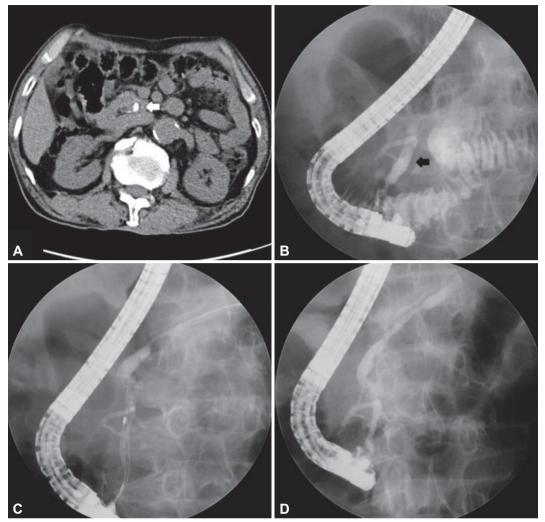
Endoscopic intervention after extracorporeal shock wave lithotripsy (ESWL) for fragmentation of large stone. (A) Abdominal computed tomographic scan shows 10 mm sized calcified stones (white arrow) in pancreatic head within markedly dilated pancreatic duct. (B) Large pancreatic duct stones in the pancreas head (black arrow) rendered the catheter impassable. (C) After two sessions of ESWL, stones were fragmented to the degree that can be removed with basket. (D) No filling defect was observed in the main pancreatic duct after complete stone removal.
